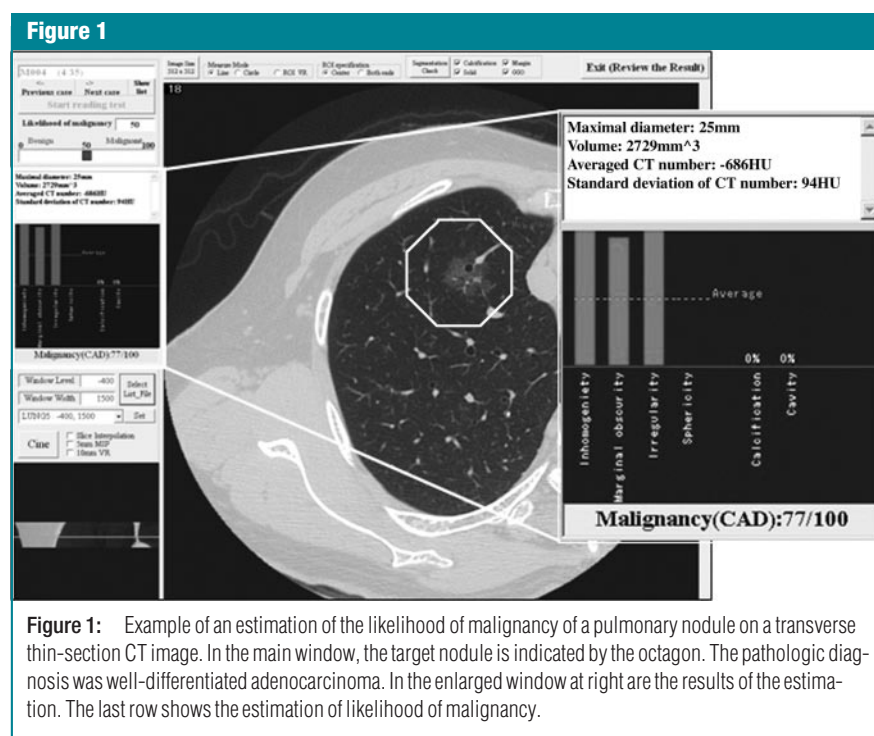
Example of an estimation of the likelihood of malignancy of a pulmonary nodule on a transverse thin-section CT image. In the main window, the target nodule is indicated by the octagon. The pathologic diagnosis was well-differentiated adenocarcinoma. In the enlarged window at right are the results of the estimation. The last row shows the estimation of likelihood of malignancy.
